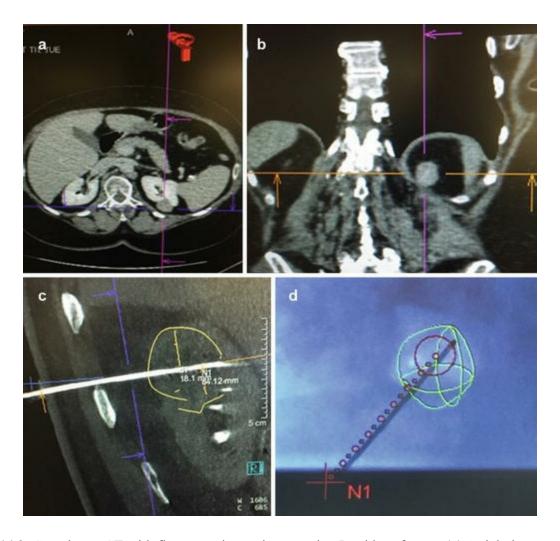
Cone beam CT with fluoroscopic precise targeting I-guide software. (a) Axial view preplanning (b) Coronal view pre-planning (c) Reimaging after needle placement in line with the needle. (d) Fluoroscopic confirmation of projected target
